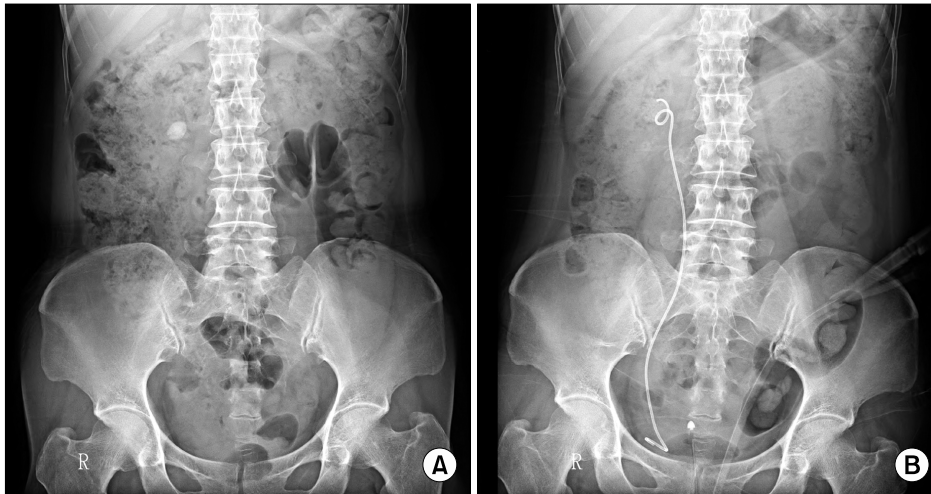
(A) A plain radiograph image of a 2 cm radiopaque stone in the right renal pelvis. (B) After ureteroscopic lithotripsy, the stone was no longer present.
